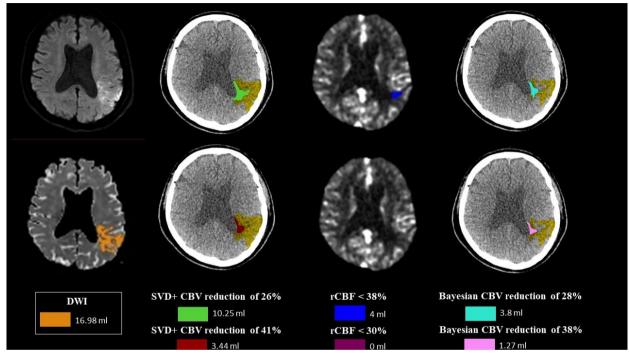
A 77 year-old man with right hemispheric stroke. The initial NIHSS score was 9 and the time between CTP to MRI was 35 min. The infarct core volume was estimated 16.98 ml with DWI-ADC (orange color). The CTA demonstrates occlusion of the left M2 division. The infarct core volume was calculated 3.44 ml on SVD+ VITREA CBV reduction of 41% (red color), 10.25 ml on SVD+ VITREA CBV reduction of 26% (green color), 1.27 ml on BAYESIAN VITREA CBV reduction of 38% (pink color), 3.8 ml on BAYESIAN VITREA CBV reduction of 28% (turquoise color), 0 ml on RAPID rCBF < 30% (purple color), and 4 ml on RAPID rCBF < 38% ml (blue color).
